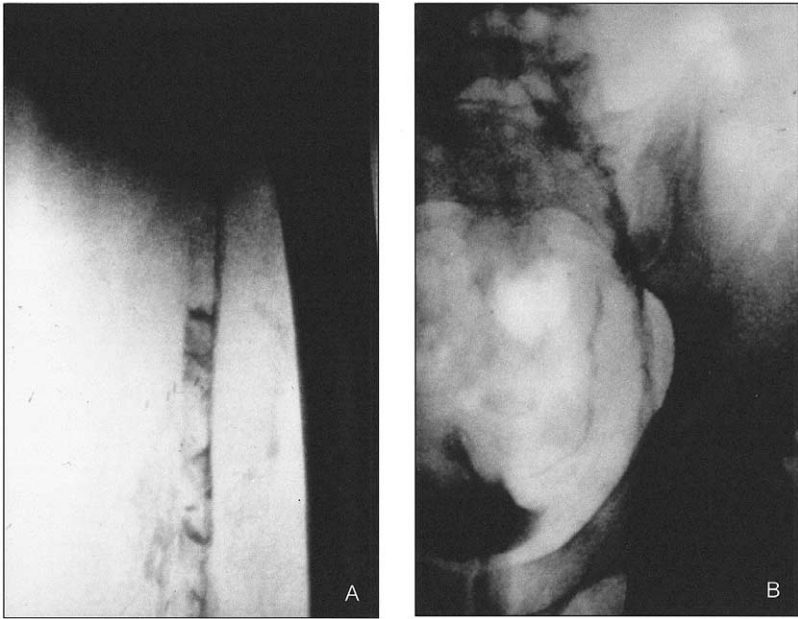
The initial ascending phlebogram of a patient with acute iliofemoral DVT demonstrates acute thrombus in the femoral vein (A) and the iliac veins (B). Following intrathrombus catheter-directed thrombolysis via an ultrasound-guided popliteal vein approach, patency is restored to the femoral vein (C) and the iliofemoral venous system (D). However, lysis revealed an underlying left common iliac vein stenosis. The stenosis is improved following balloon angioplasty, but it is not corrected (E). Following stenting of the left common iliac vein, unobstructed venous drainage into the vena cava is achieved (F). The patient was therapeutically anticoagulated with a warfarin compound and remains asymptomatic.
